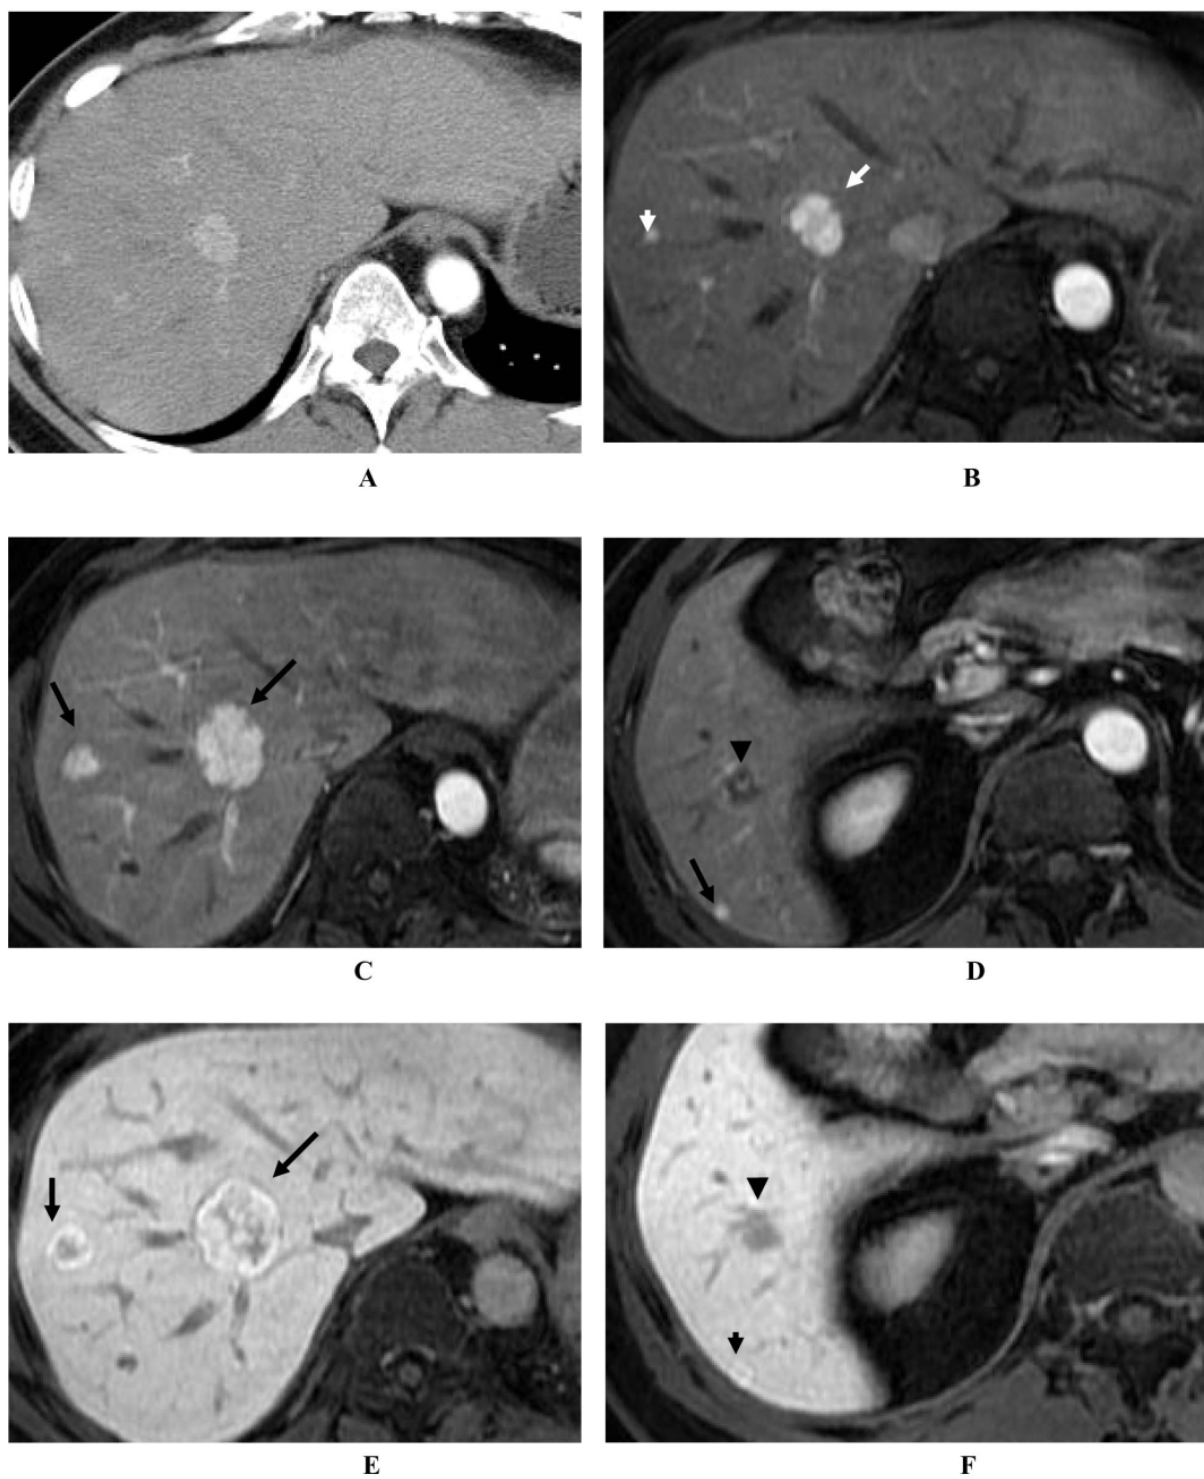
Liver Imaging. A: CT scan upper abdomen, B: MRI liver, C and D: MRI with a hepatocyte specific contrast, Gd-EOB-DTPA injection; (arterial phase), E and F: MRI with a hepatocyte specific contrast, Gd-EOB-DTPA injection (hepatobiliary phase).
